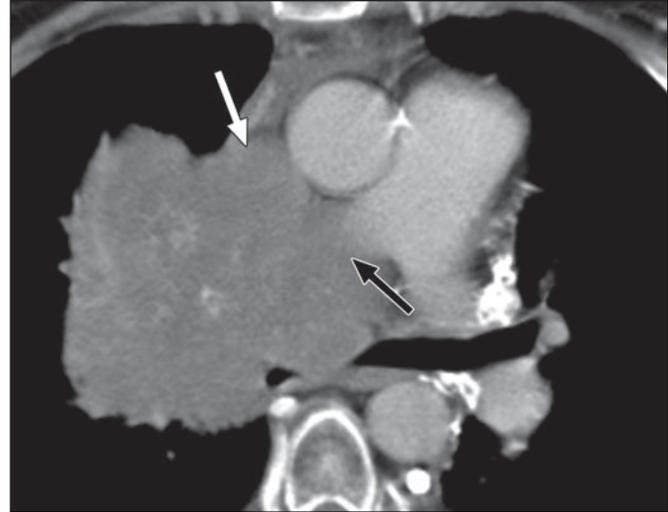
40-year-old woman who smokes two packs of cigarettes per day. Axial CT image shows very large mass invading mediastinum with obstruction of superior vena cava (white arrow) and right pulmonary artery (black arrow). Small-cell carcinoma, which is highly associated with smoking, was found on biopsy.
